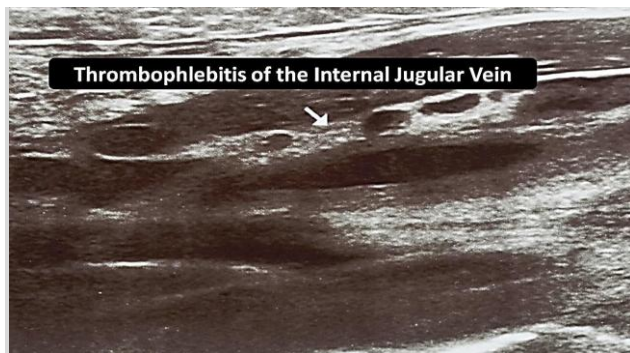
Ultrasound imaging thrombophlebitis of the left internal jugular vein.
